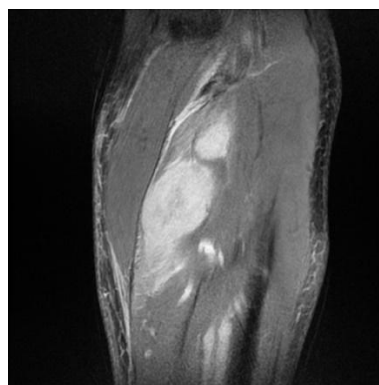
MRI of the left calf in coronal section showing lesions of the internal gastrocnemius and of the anterior tibial muscles
